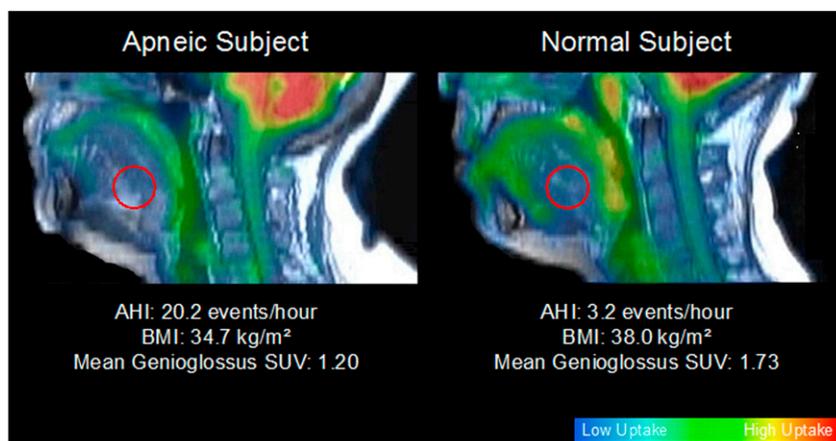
Representative female patient with sleep apnea with reduced [¹⁸F]-2-fluoro-2-deoxy-D-glucose uptake in genioglossus in comparison with control female subject on fused positron emission tomography-magnetic resonance images. Note that standardized uptake value (SUV) in genioglossus of the patient with sleep apnea is reduced in comparison with the control subject. AHI = apnea-hypopnea index; BMI = body mass index.
